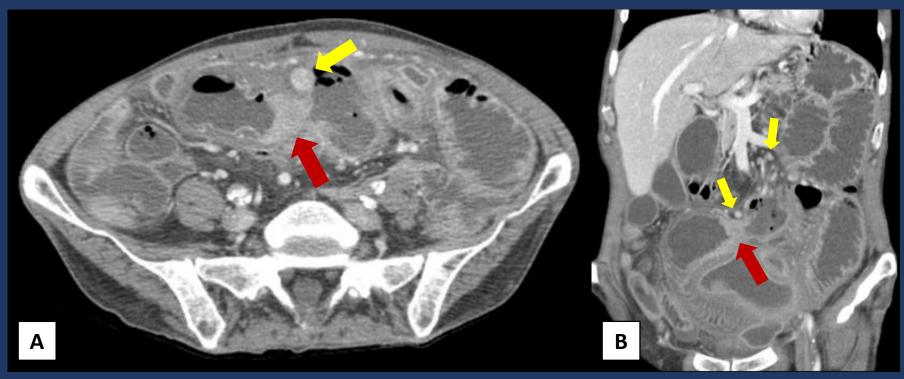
Axial (A) and coronal (B) CT images showing an "apple core" adenocarcinoma (red arrow) and adjacent mesenteric adenopathies (yellow arrow) with associated small bowel obstrution, in a cachectic patient (note the absence of subcutaneous and intra-abdominal fat).
